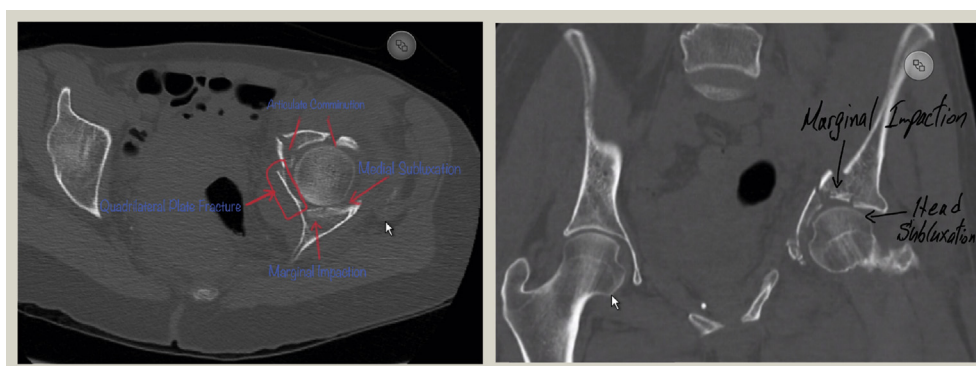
Axial and coronal CT scan cuts demonstrating key features of osteoporotic acetabular fractures.
